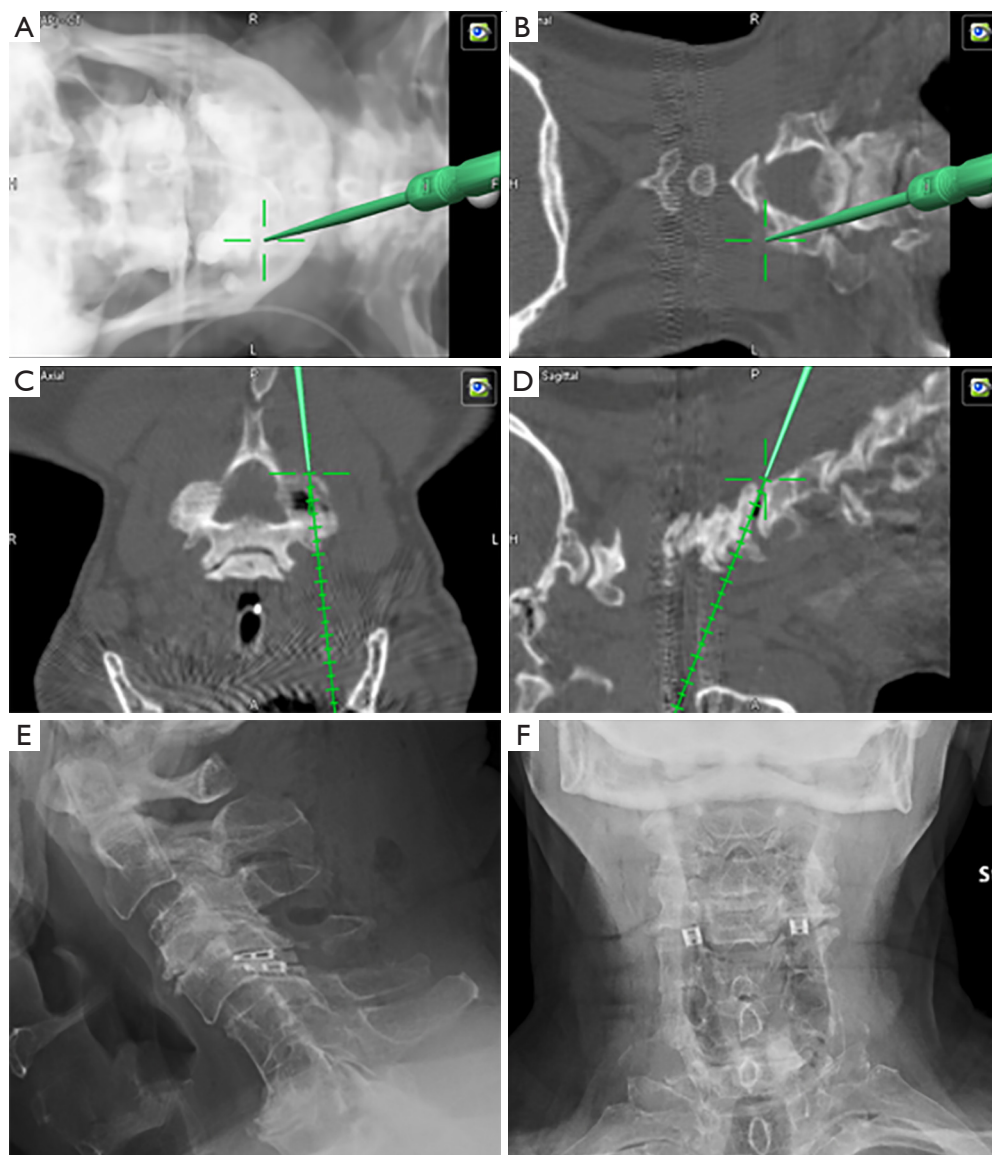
Intraoperative 3D navigation screenshots demonstrating the trajectory and ultimate target of the interfacet joint cage (A,B,C,D). Postoperative (E) lateral and (F) anteroposterior radiographs following bilateral interfacet joint cage implantation. With permission of ref. (87).
